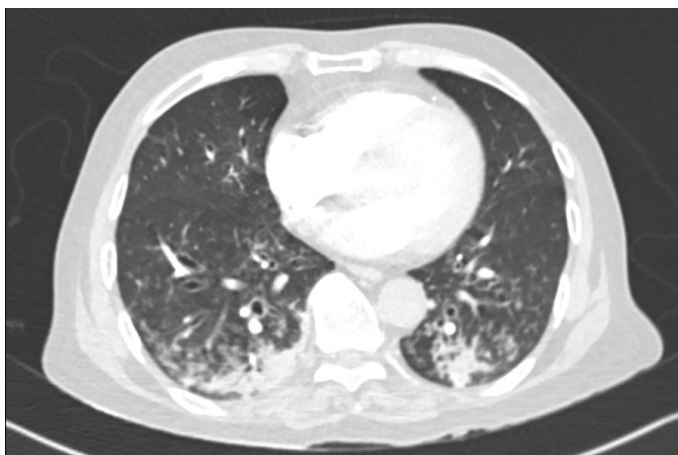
Non enhanced axial view high resolution CT chest.
